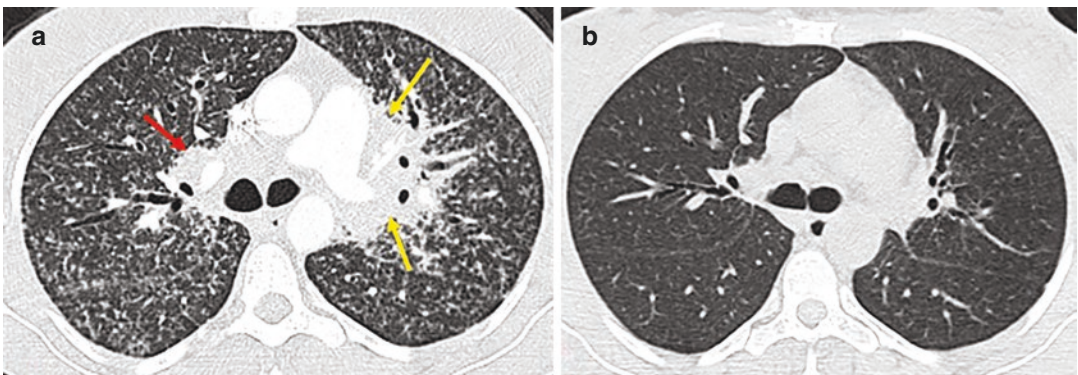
Miliary sarcoidosis in a 32-year-old woman. (a and b) Axial HRCT images show randomly distributed micronodules in both lungs (a) that disappeared after
